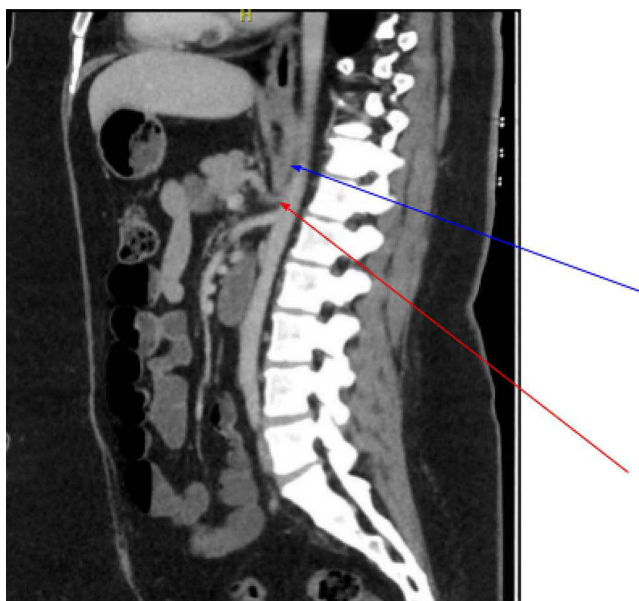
Median Arcuate Ligament Syndrome (MALS) on CT Angiogram in a patient with EDS. The blue arrow points to the median arcuate ligament. The red arrow shows the tight stenosis of the coeliac trunk as it passes under the MAL.
